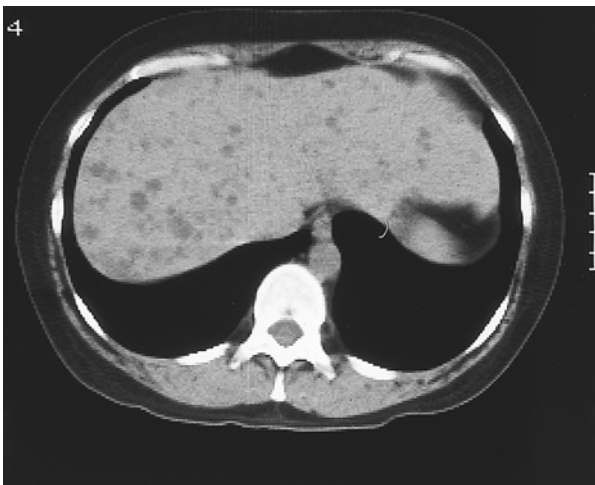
The review CT scan (7.30.90) shows the low density foci in the liver that were diagnosed as liver cysts at this examination.
